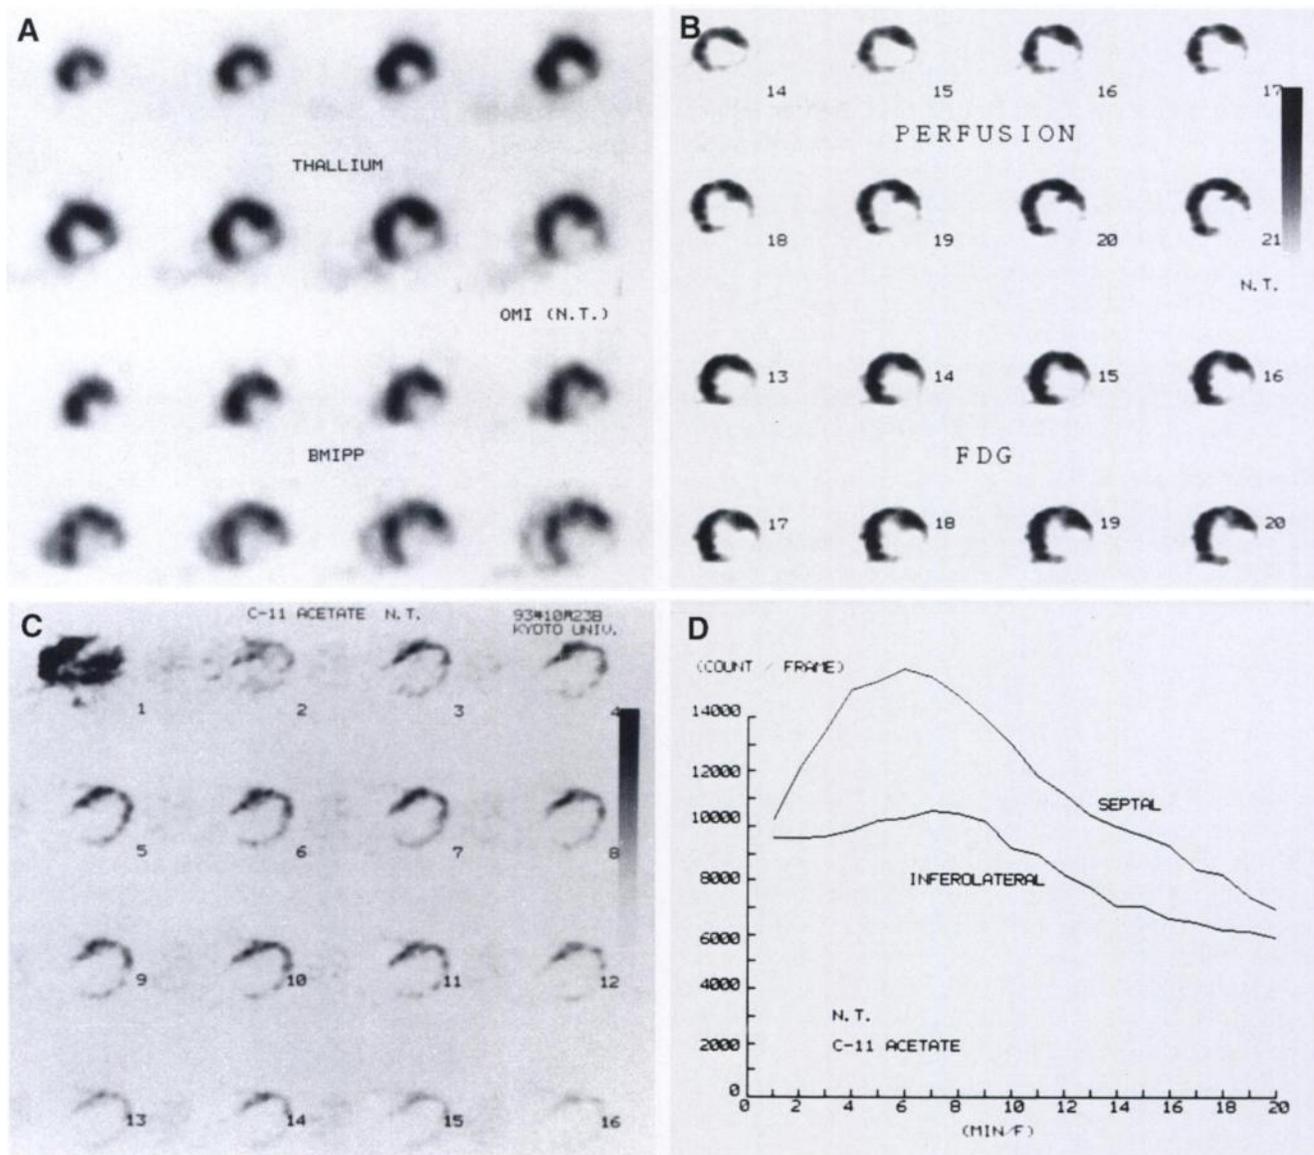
(A) Series of short-axis slices of ²⁰¹Tl (top) and BMIPP images (bottom) show a perfusion defect with concordant decrease in BMIPP distribution in the posterolateral region in a 76-yr-old man with inferior wall myocardial infarction. (B) Series of short-axis slices of perfusion and FDG images show similar decrease in perfusion and FDG uptake (matched defect) in the posterolateral region. (C) Serial dynamic PET images after administration of ¹¹C-acetate show decreased tracer uptake in the posterolateral region with delayed clearance. (D) Time-activity curves of the septal and posterolateral regions show decreased uptake and delayed tracer clearance in the posterolateral region, indicating reduced oxidative metabolism.
